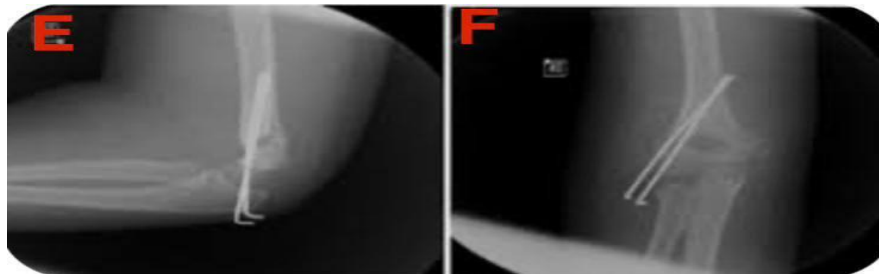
X-ray of intraoperative AP and lateral views showing maintained alignment and bicortical purchase of the pins
